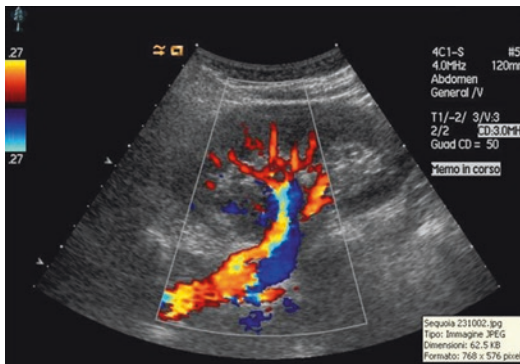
Kidney's lateral scan identifying intrarenal vascularization, main branches, and the renal artery. The lateral decubitus position is essential, because the kidney itself acts as a sonographic window making visible intrarenal vascularization, main branches of the renal artery, and the renal artery. Doppler angle is optimal and US beam is pointed in the line of arterial flow
